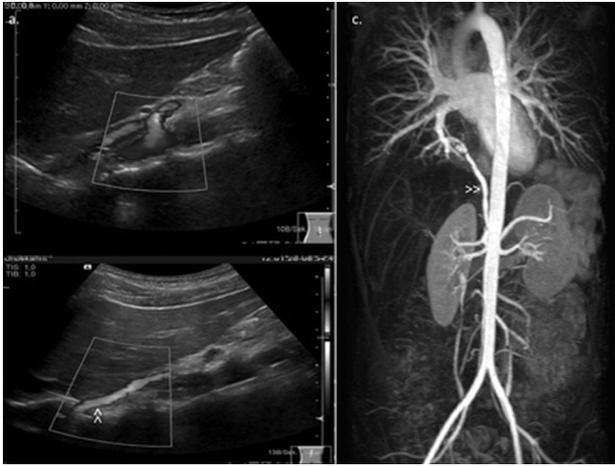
Abdominal Ultrasound (CCDS) and MR-Angiography showing an aberrant vessel from the celiac trunk to a lung sequester in the right lower lobe.
